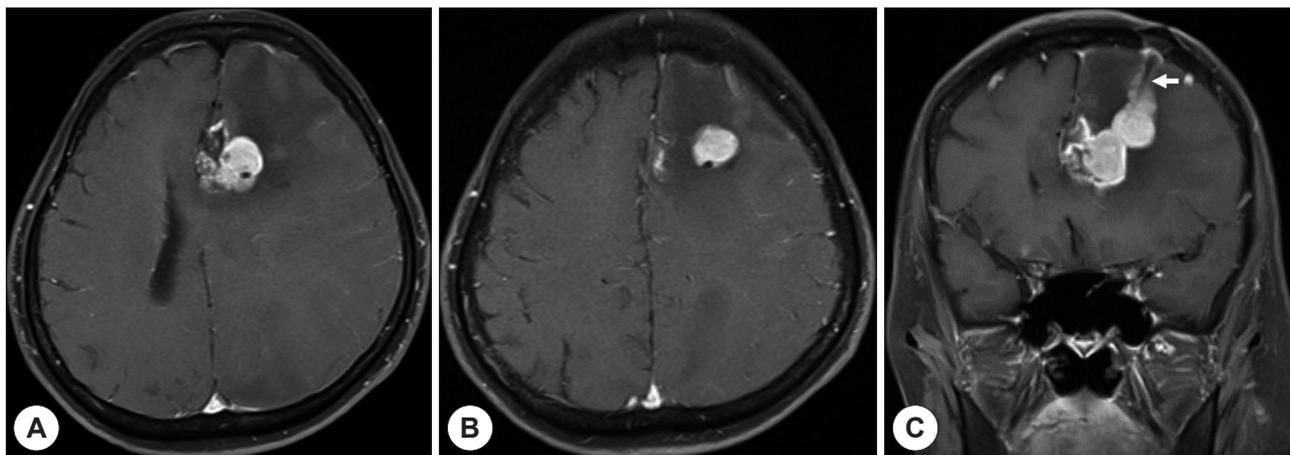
Gadolinium-enhanced T1-weighted MRI scans 6 months after GKS. A : Axial scan in the plane of the large metastatic mass. B : Axial scan in a more cranial plane than A. C : Coronal scan showing metastatic lesions along Ommaya cannula (arrow).
